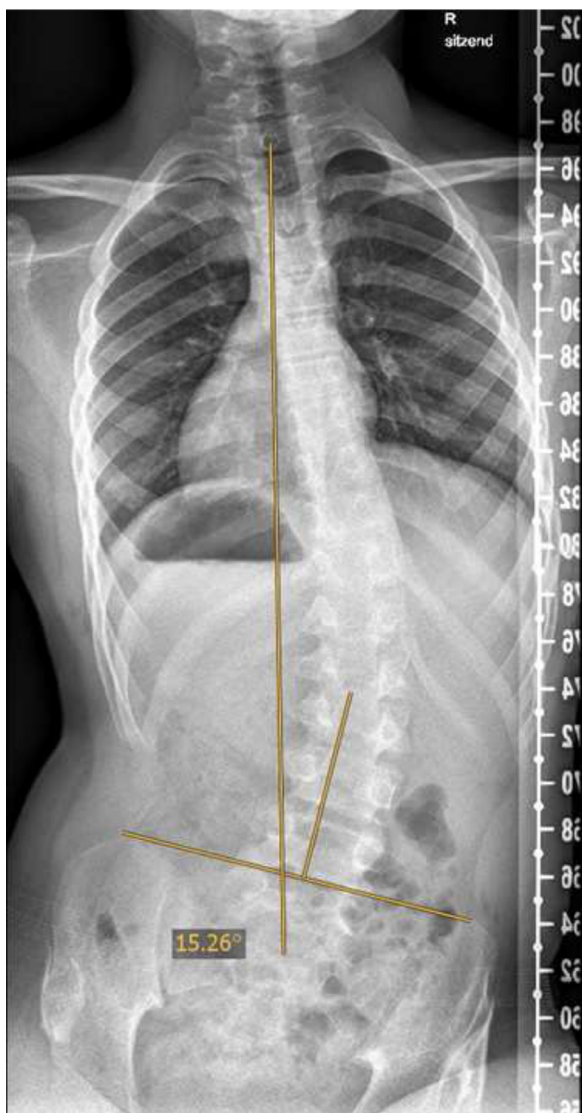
AP total spine radiograph with pelvic obliquity measurement according to Maloney [15] in yellow. The angle is measured between a perpendicular line to the connection of the iliac crests and T1 to S1.
